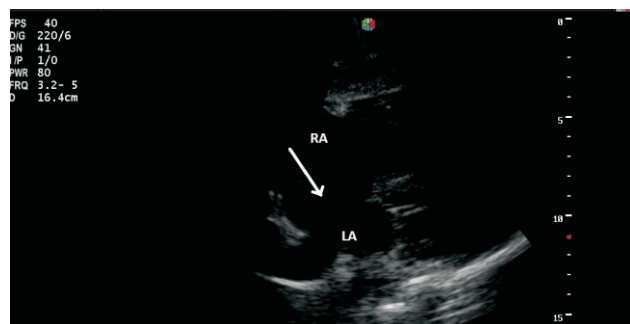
Echocardiogram (subcostal view) showing large ASD (Arrow). RA-right atrium, LA- left atrium
